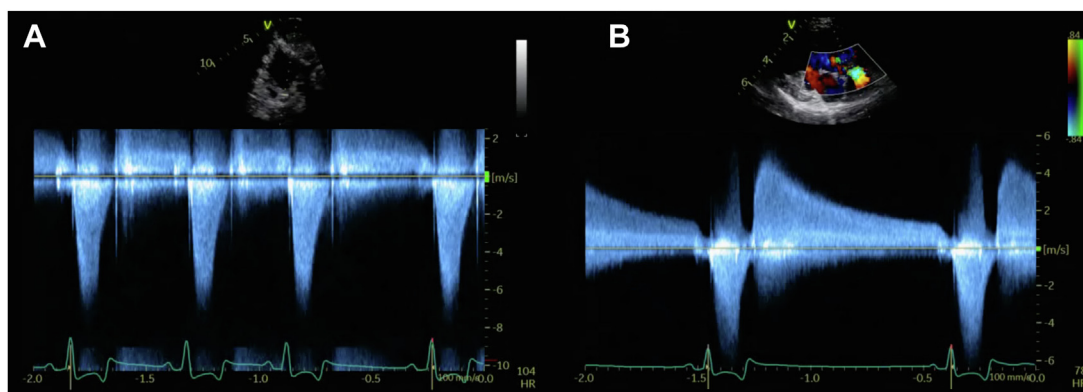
Two-dimensional TTE-guided continuous-wave Doppler spectral display of the aortic valve from the subcostal (A) and right parasternal long-axis (B) views. Peak aortic systolic velocity was markedly increased at 7.25 m/sec (pressure gradient 210 mm Hg), and peak velocity of the retrograde flow was 4.7 m/sec (91 mm Hg).
